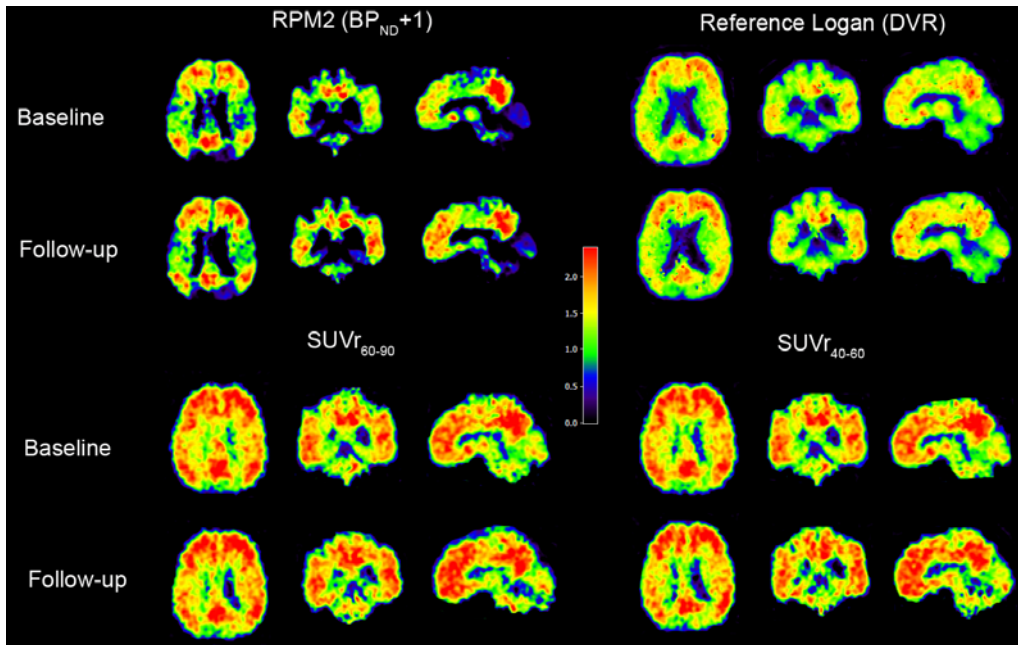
Parametric images of an AD patient with 27 months of follow-up, showing increased RPM2 $BP_{ND}+1$ (4%), Reference Logan DVR (2%) and $SUVR_{40-60}$ (2%), whereas $SUVR_{60-90}$ decreased with 10%. R1 was 2% lower at follow-up.
